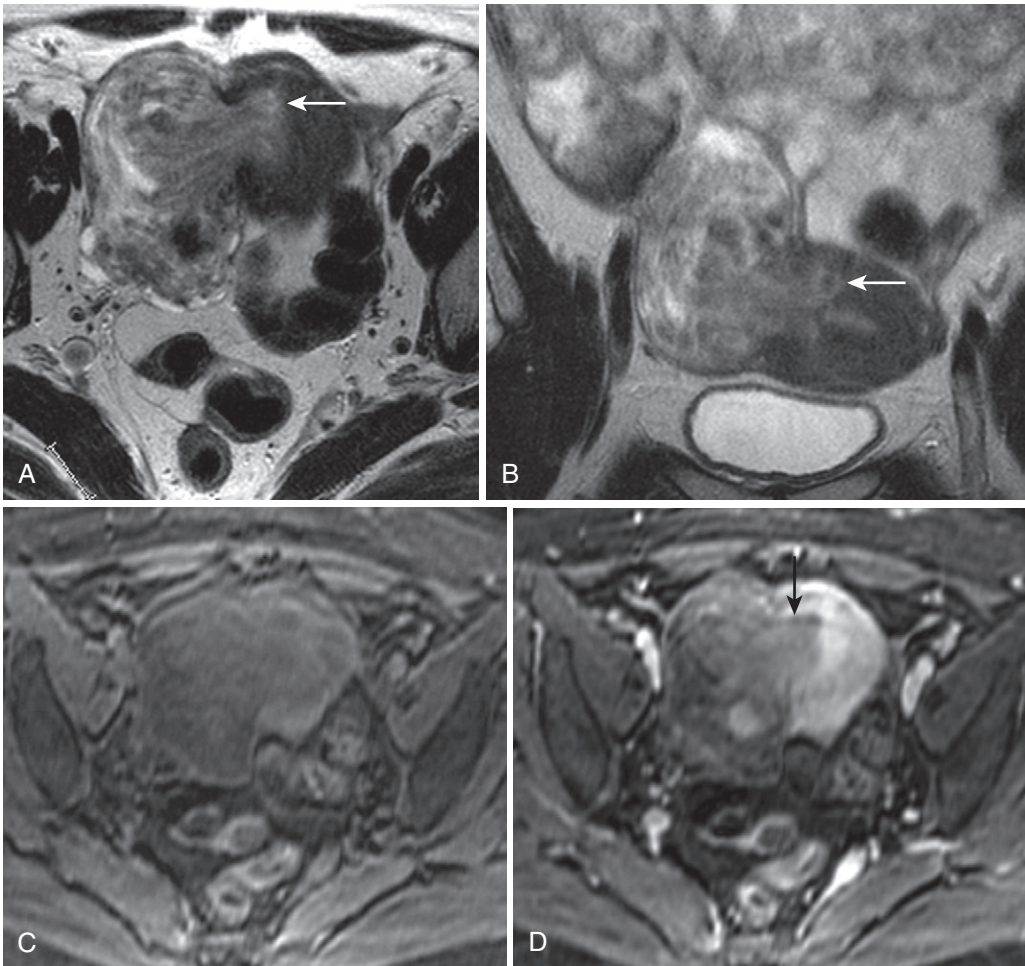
Malignant degeneration of a fibroid. Axial (A) and coronal (B) T2-weighted images show a moderately heterogeneously hyperintense ovoid lesion adjacent to the uterine fundus attached to the uterus with ill-defined margins in contradistinction to the normally sharply defined stalk seen with a benign leiomyoma, indicating invasion of the adjacent myometrium (*arrow*). Differential enhancement between the enhancing myometrium (*thick arrow* in D) and hypovascular mass (*thin arrow* in D) is evident when comparing the precontrast image (C) with the postcontrast image (D).
